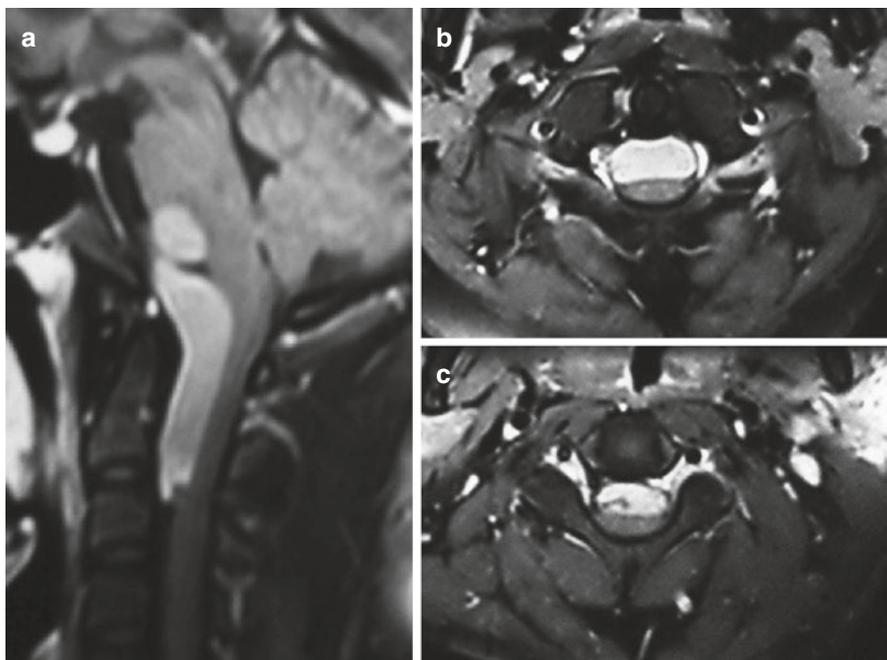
(a) Contrast T1 sagittal MR image of the craniovertebral junction (CVJ) showing an anteriorly placed neurenteric cyst with an indentation caused by the traversing vertebral artery. (b, c) Contrast-enhanced axial T1 MR images showing the lesion situated anterior to the cervical cord. (From Shukla et al. [14]; with permission)
